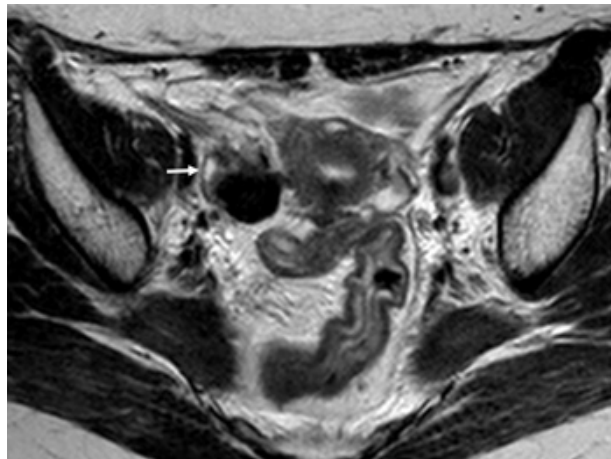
Brenner tumour. Pelvic MRI of a 39-year-old woman, where it is possible to observe a T2 hypointense lesion, surrounded by normal ovarian parenchyma. The tumour deforms the edge of the ovary into a beak shape (beak sign) A small ovarian follicle can be identified at the periphery (arrow). These findings favour its origin in the right ovary.
